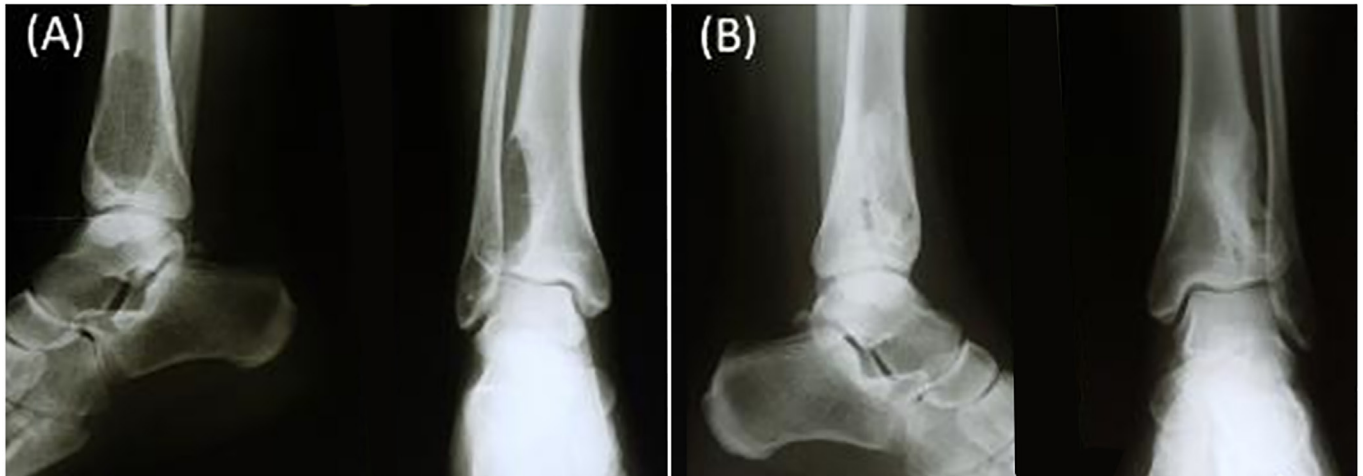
A) Anteroposterior and lateral radiograph of a 25-year-old female with distal tibia giant cell tumor (of bone) B) Two years after extended curettage and bone graft.
